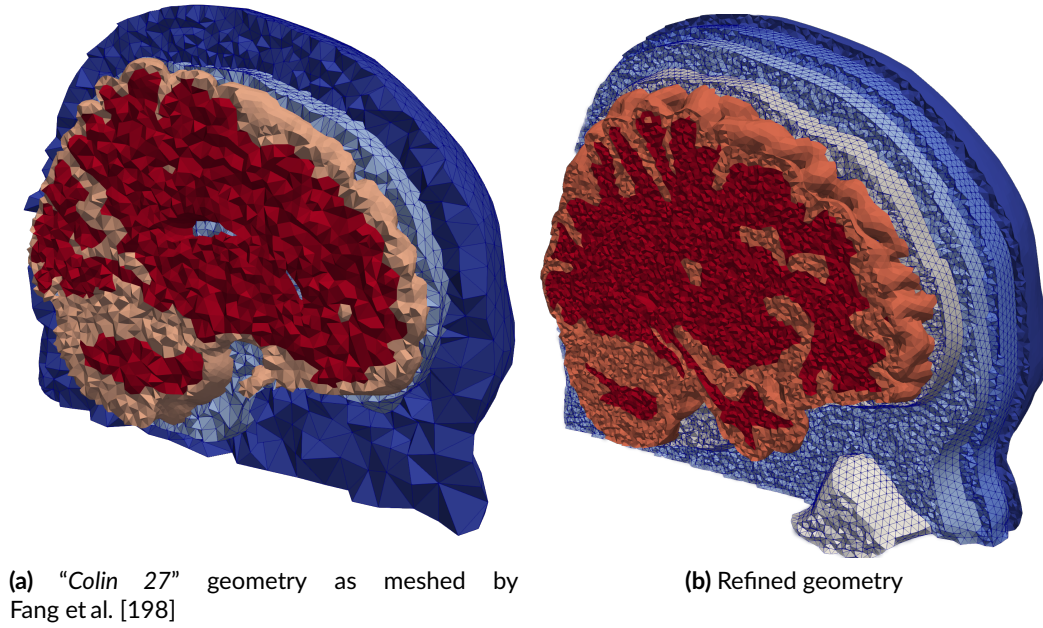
The geometric head model based on the “Colin 27” [195] brain atlas. Each color indicates a different material. From outside to inside: (a) outer shell, CSF, GM, and WM; (b) scalp, skull, CT, CSF, GM, and WM, lateral ventricles, sinuses. (Except for the CSF, all other materials were separated in left and right hemisphere for the refined mesh.
